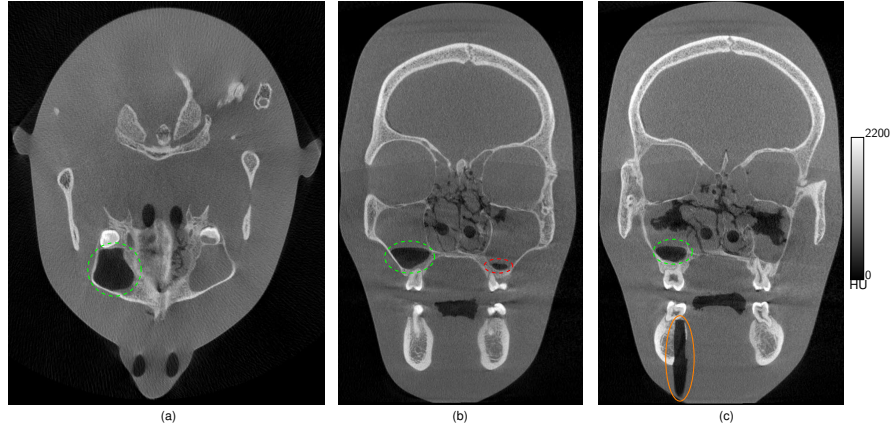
An axial and two coronal slices showing the same details in the CBCT image as in the two pan images. From the CBCT image, it is confirmed that there are indeed air gaps in the highlighted positions. The visible soft tissue boundary in (b) and (c) around eye sockets' upper part marks the two rotations' stitching boundary. [Adapted from [80]]
